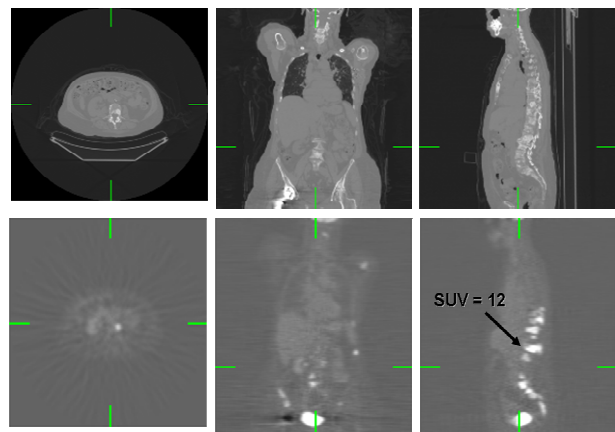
Top: Axial, sagittal and coronal views of the 70 cm FOV - CT image. Bottom: PET images with elevated levels of FDG uptake in bone.
